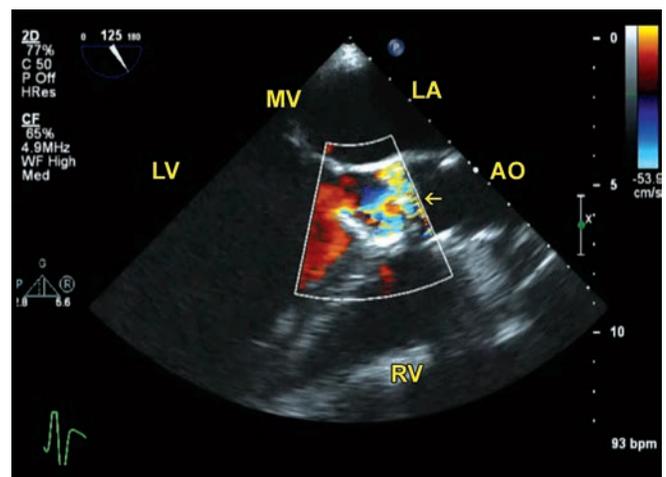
TTE midesophageal long-axis view: Color Doppler.
